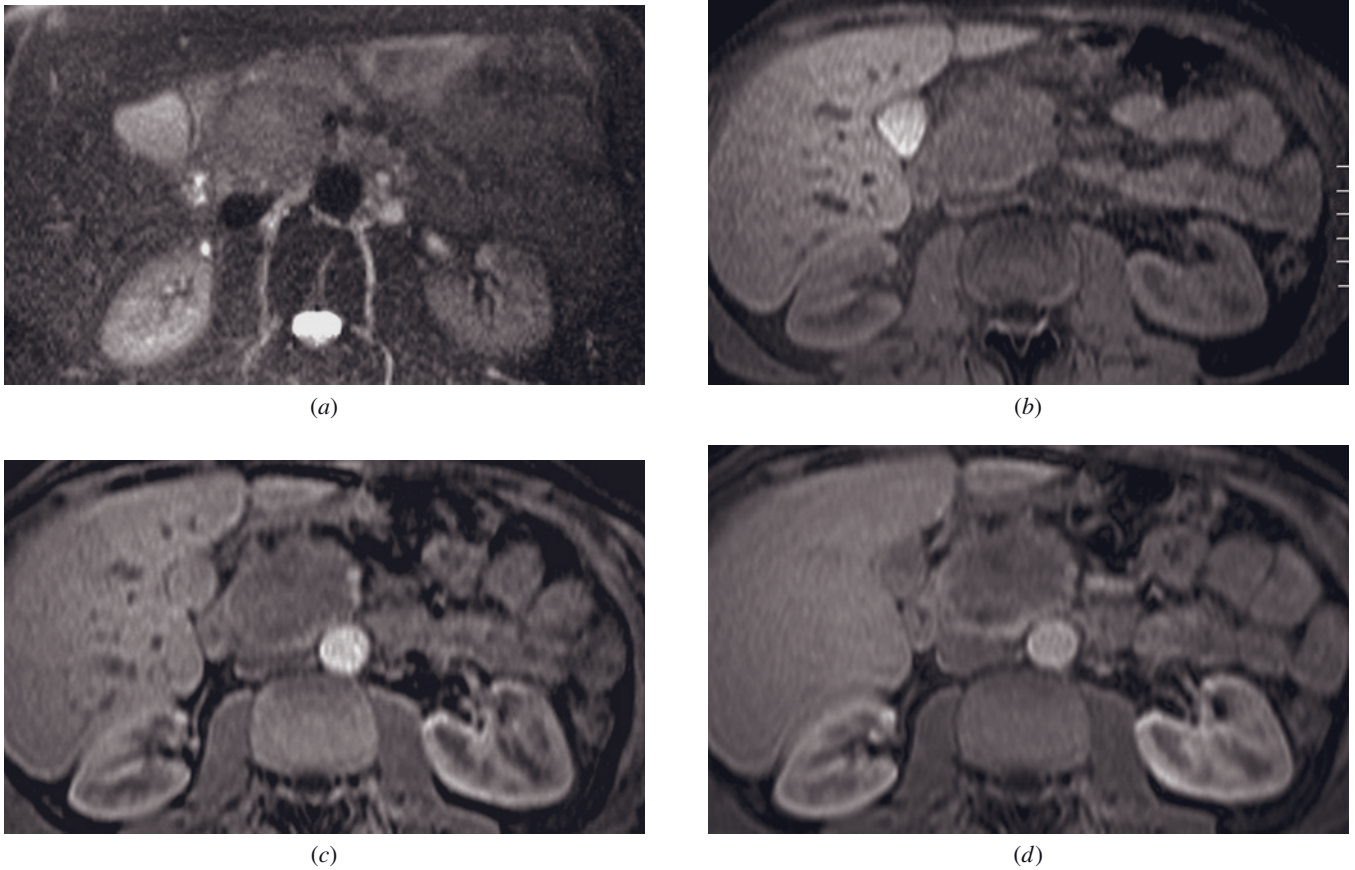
Large pancreatic cancer arising in the head. Fat-suppressed T2-weighted SS-ETSE (a), fat-suppressed T1-weighted gradient-echo (b), and immediate (c) and interstitial-phase (d) postgadolinium fat-suppressed T1-weighted gradient-echo images in a patient with pancreatic cancer. A 5-cm mass is present in the pancreatic head. It is mildly hypointense relative to pancreas and demonstrates diminished enhancement on immediate and late postgadolinium T1-weighted images (c, d).
